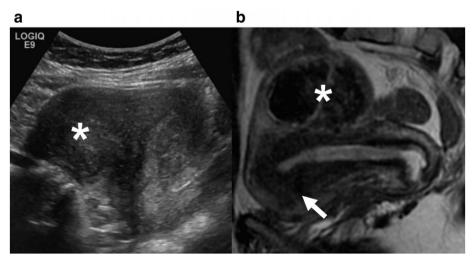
Images from a 50-year-old woman presenting with dysmenorrhea and menorrhagia. (a) Sagittal view of the uterus from a pelvic US demonstrating a posterior fundal uterine fibroid (white asterisk). (b) Sagittal T<sub>2</sub>-weighted single-shot fast spin echo image from a pelvic MRI performed 3 months after the US identified the previously seen posterior fundal fibroid (white asterisk), and revealed findings of adenomyosis, including a thickened junctional zone measuring 18 mm (white arrow). Adenomyosis commonly results in painful periods with heavy bleeding, whereas the intramural fibroid would not be expected to explain the patient's presenting symptoms.
